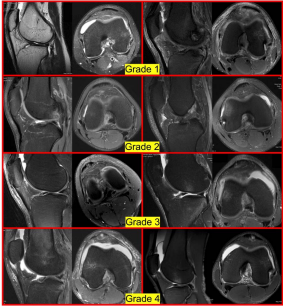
Axial and sagittal fat-suppressed magnetic resonance imaging (MRI) images of patellar tendinopathy grading used for this cohort.
